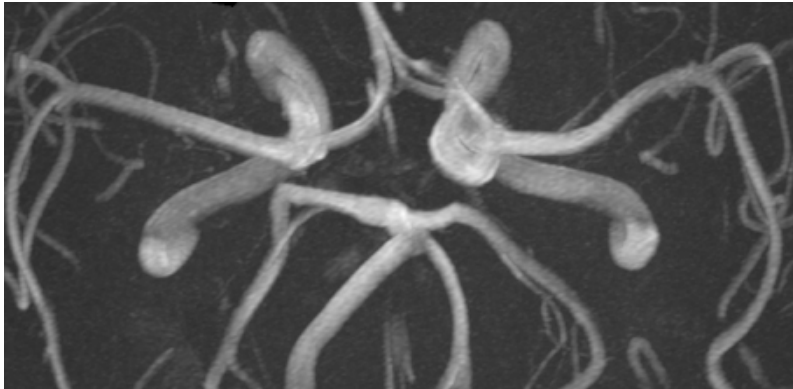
Magnetic resonance angiography (MRA) images of patient from 3 T MRI scanner viewed from the top with background brain tissue.
